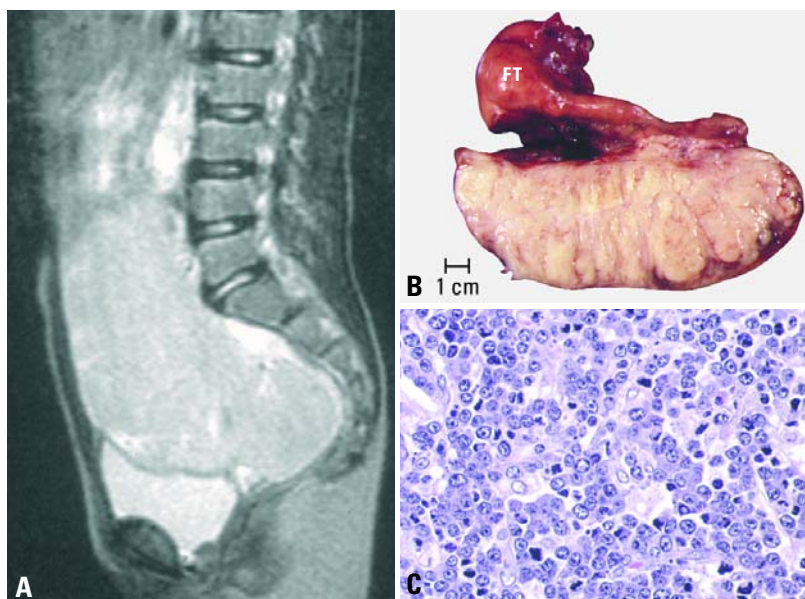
Burkitt-like lymphoma. A T2 weighted sagittal computed tomography scan from an 8-year old girl shows a large pelvic mass. B Sagittal section of the ovarian tumour shows a homogeneous, pale surface. Notice the enlargement of the fallopian tube (FT). C A starry-sky pattern is apparent (B5 fixation).
